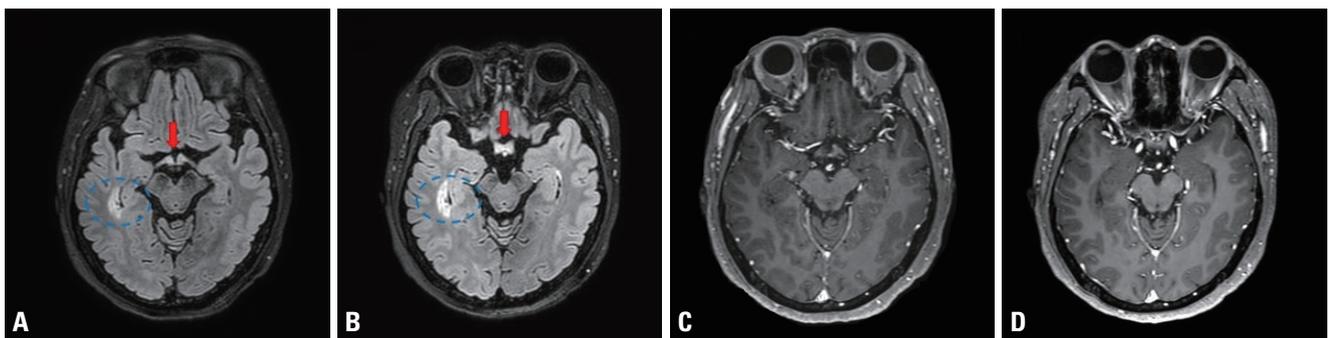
Serial brain MRI revealed the disease exacerbation shortly following RTX treatment. FLAIR MRI revealed hyperintense lesions at the optic chiasm (red arrow) and right temporal horn of the lateral ventricle (blue dot circle) at 1 month prior to the initial RTX infusion (A) and at 2 weeks posttreatment (B). (C, D) Post-enhancement images corresponding to (A) and (B), respectively, revealing mild gadolinium enhancement with no significant changes. MRI, magnetic resonance imaging; RTX, rituximab; FLAIR, fluid attenuated inversion recovery.
